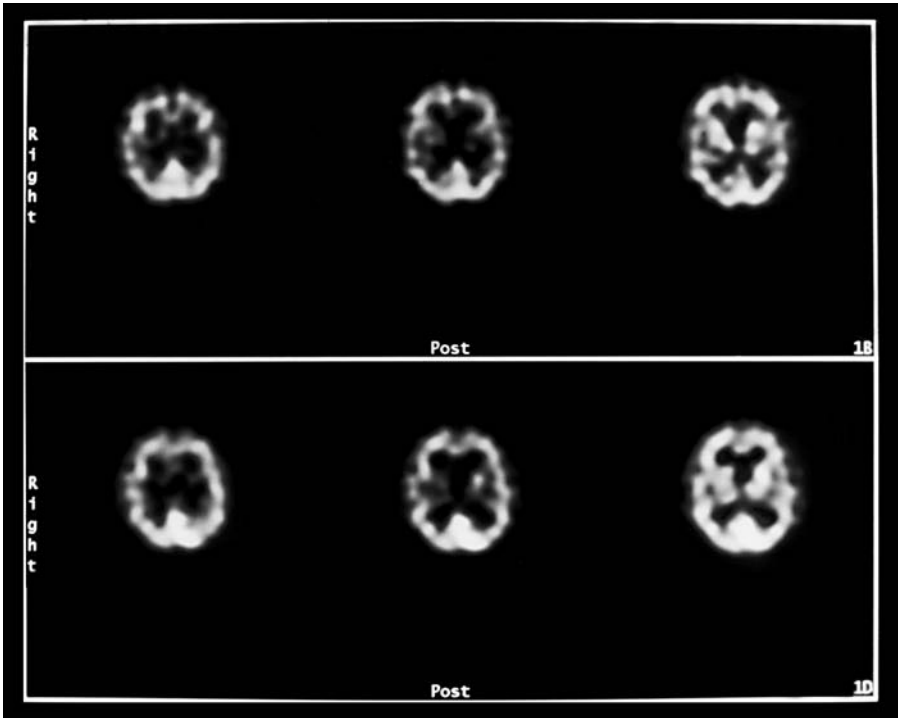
The pictures on this SPECT scan were obtained at two different times and displayed one on top of the other to demonstrate the differences between the two states. The bottom series was done while the patient was symptomatic. They show a large area of increased blood flow posteriorly and to the left. The top three scans are matched for areas and were obtained after successful resolution of symptoms. This was interpreted as normal but significantly changed.
